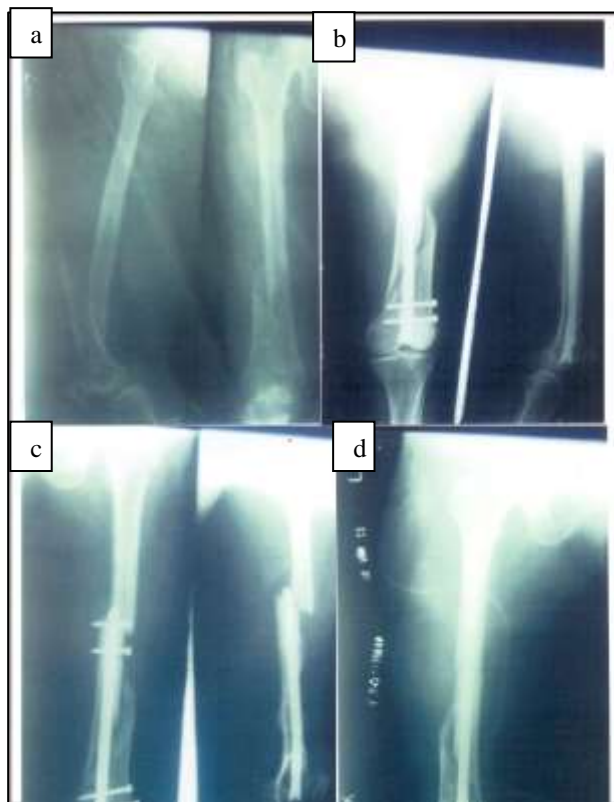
a) Preoperative X-ray showing AO type A1 distal femur fracture; b) Postoperative X-ray showing fixation with RIMN; c) Stress fracture at the tip of the nail; d) Refixation done with long RIMN.
